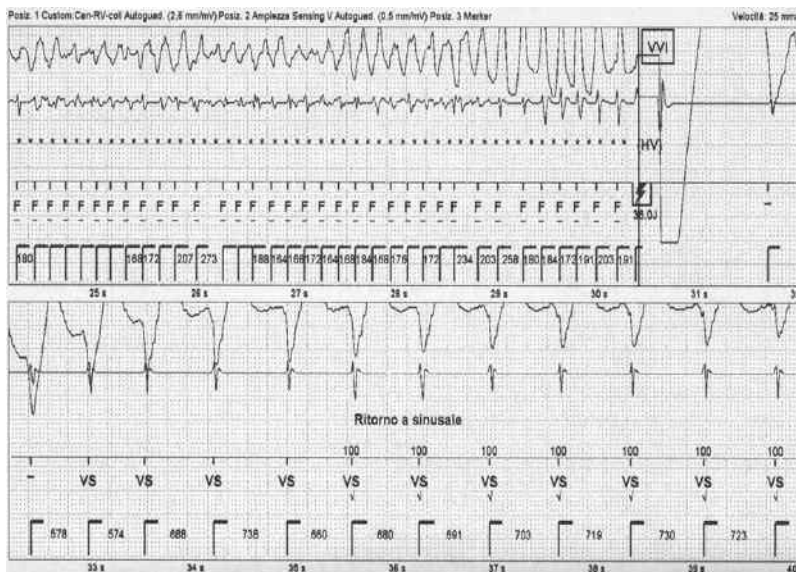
Echocardiogram shows sustained ventricular tachycardia interrupted with DC shock.
